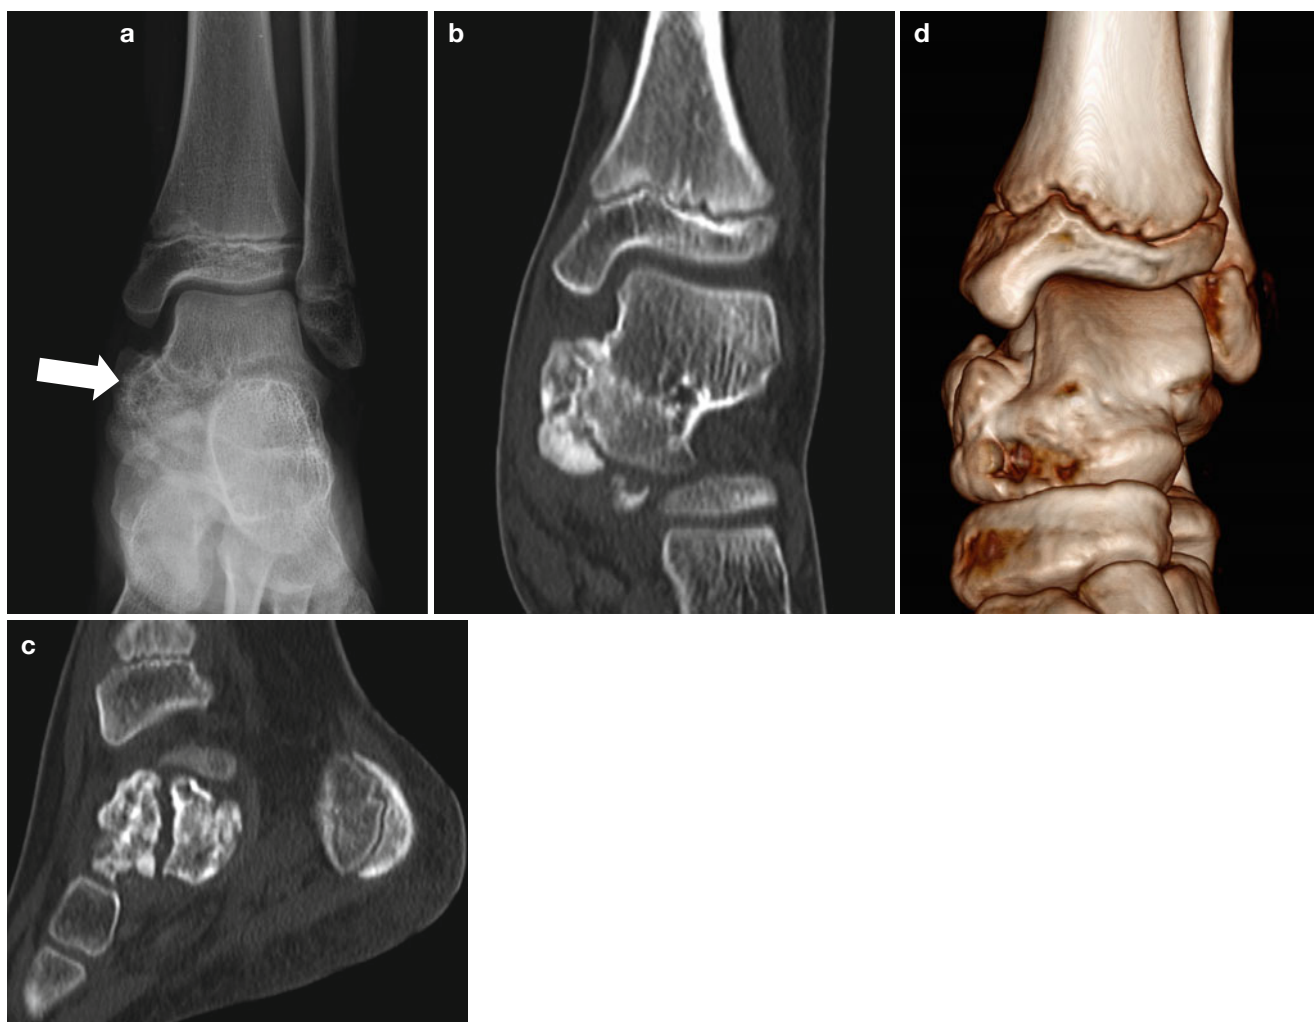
Epiphyseal dysplasia hemimelica (Trevor's disease)* in a 9-year-old girl. (a) Left ankle AP radiograph shows a protruding bony lesion with bubbly appearance (*arrow*) in the medial aspect of the left talus. (b–d) Coronal (b) and sagittal (c) CT images show a lobulating
